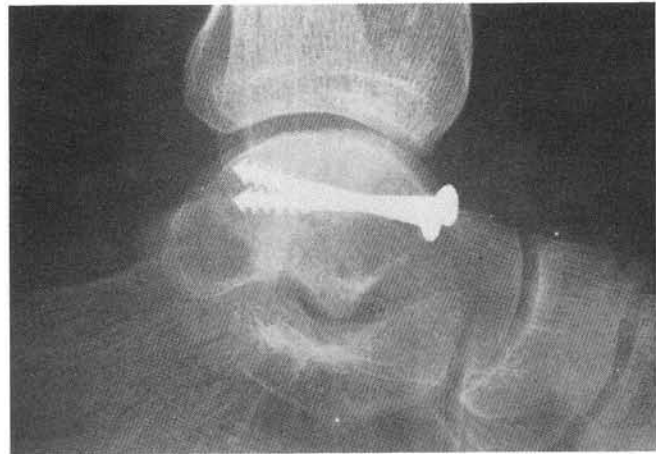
Lateral radiograph at eighteen months postoperative.
